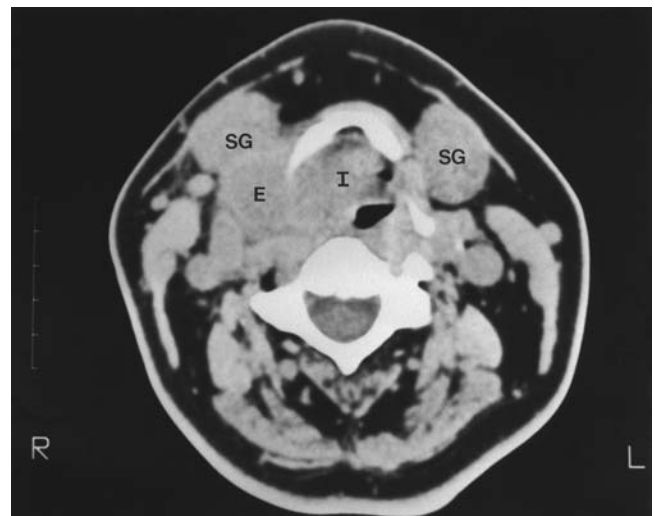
Computed tomography scan showing an infected mixed laryngocele (laryngopyocele). Both external (E) and internal (I) components are filled with dense secretions (compare with air-filled laryngocele in Fig. 15). *Abbreviation:* SG, submandibular gland. *Source:* Image courtesy of Dr. Hugh Curtin, Boston, MA.
